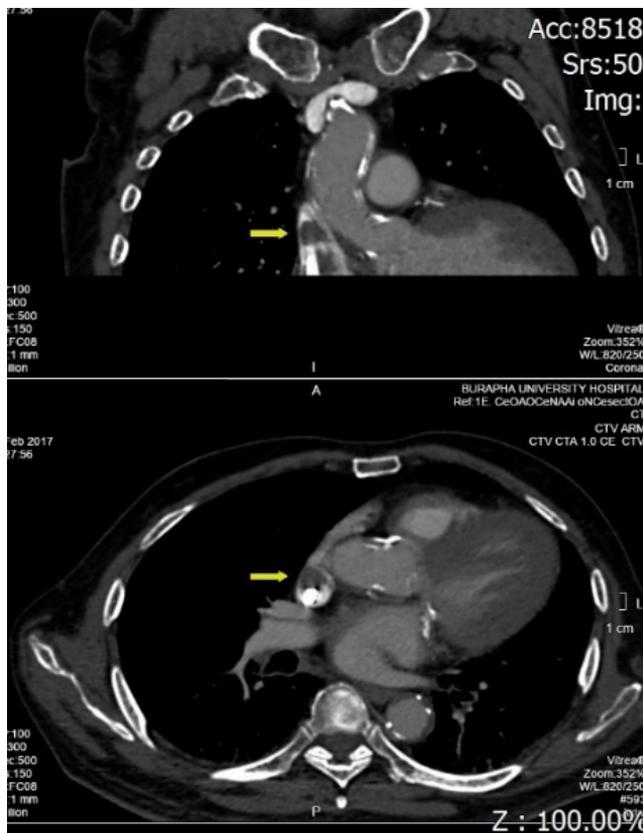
A 82 year-old male presents with failed cannulation at right internal jugular vein. Direct computed tomography venography with multiplanar reconstruction longitudinal view (top) and axial view (bottom) demonstrate thrombus in the superior vena cava (arrows).
